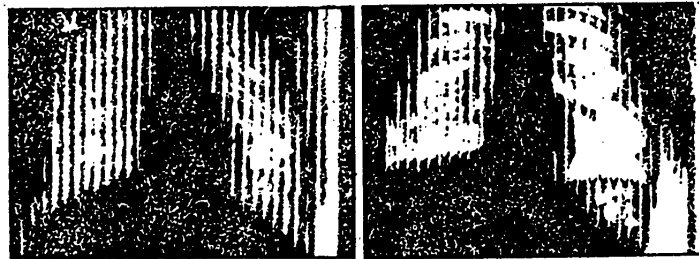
Roentgenkymogram of Respiratory Movements of the Diaphragm in Subject C. When Breathing Oxygen under Excess Pressure.
